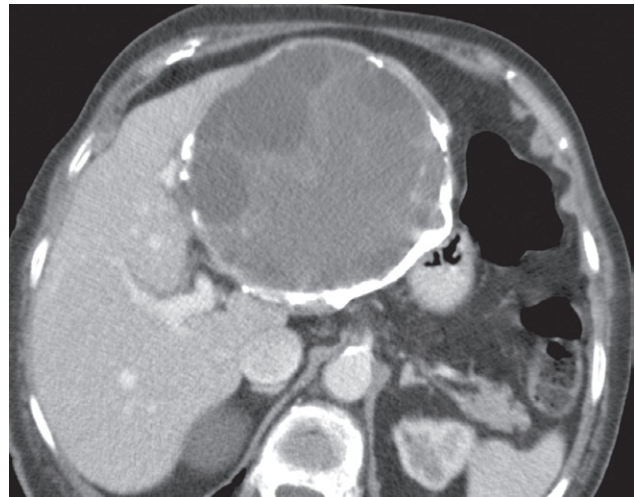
CT scan of hepatoma showing a large mass of variable density (arrows).
